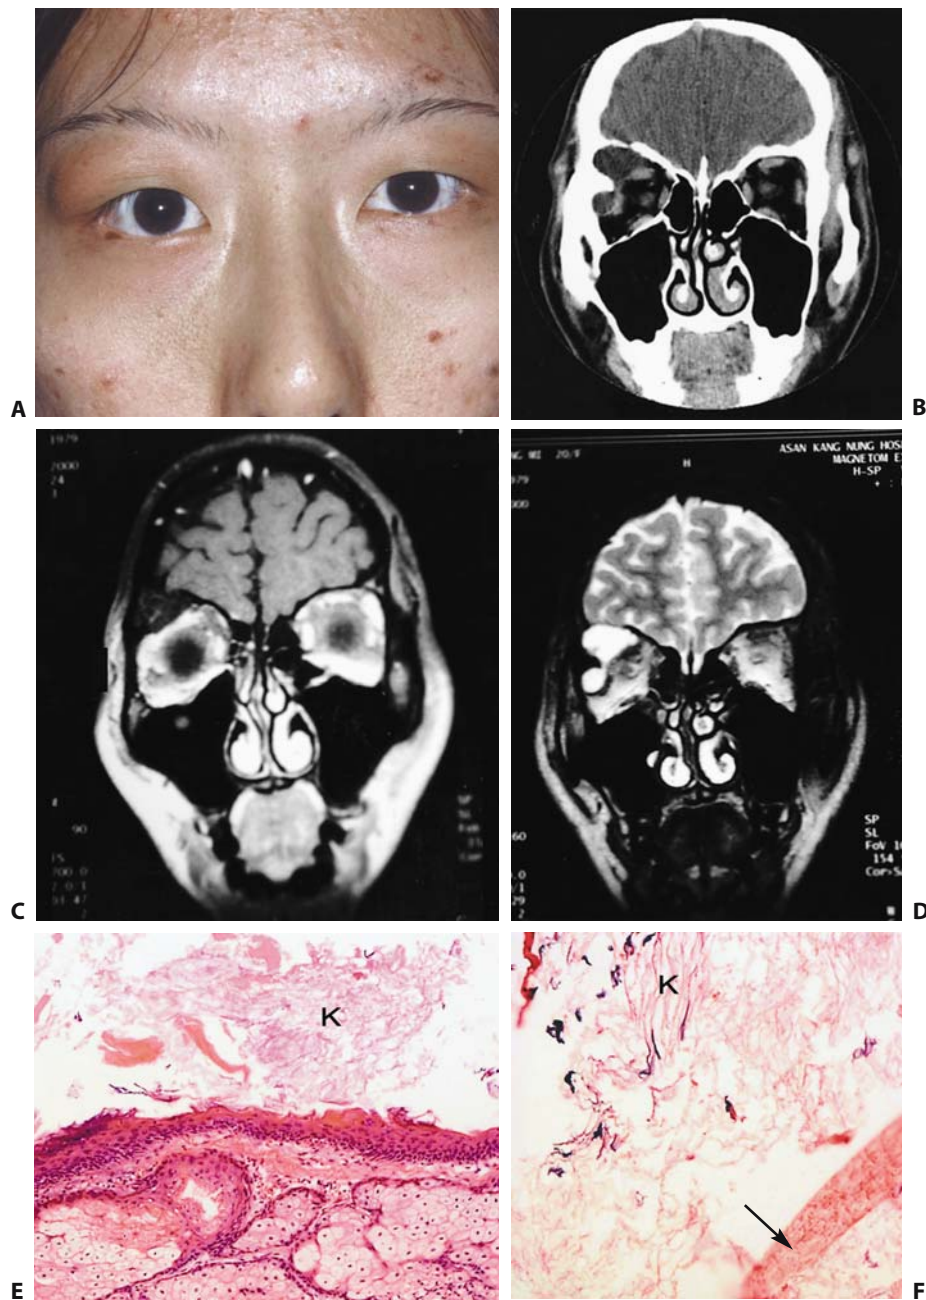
(A) Dermoid cyst in a 21-year-old woman who had experienced slowly progressive proptosis of the right eye for several years. (A) Facial photograph. (B) Coronal CT image shows a large cystic mass that erodes the superior and lateral walls of the orbit. (C) T1-weighted MR image shows a low-intensity mass with no enhancement. (D) The mass shows high intensity on a T2-weighted
